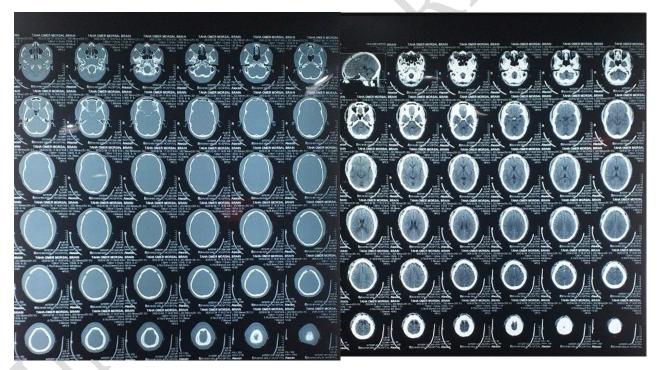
Follow up CT brain bone window showingthecraniotomyboneflapwellfixedin place *Figure 6B:* Follow up CT brain, soft tissue windowshowingadequateevacuationofthehematoma with relaxed brain and sinus in place.
